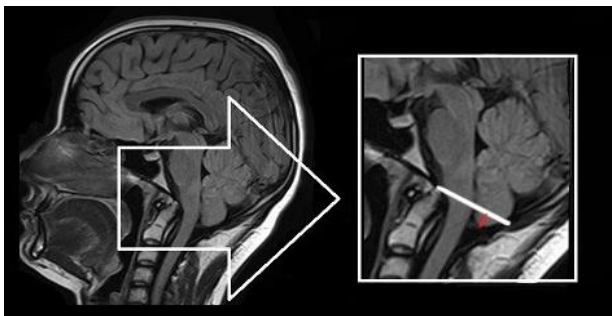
Sagittal FLAIR image demonstrating basion-opisthion line in white and tonsillar herniation measurement as a red line
